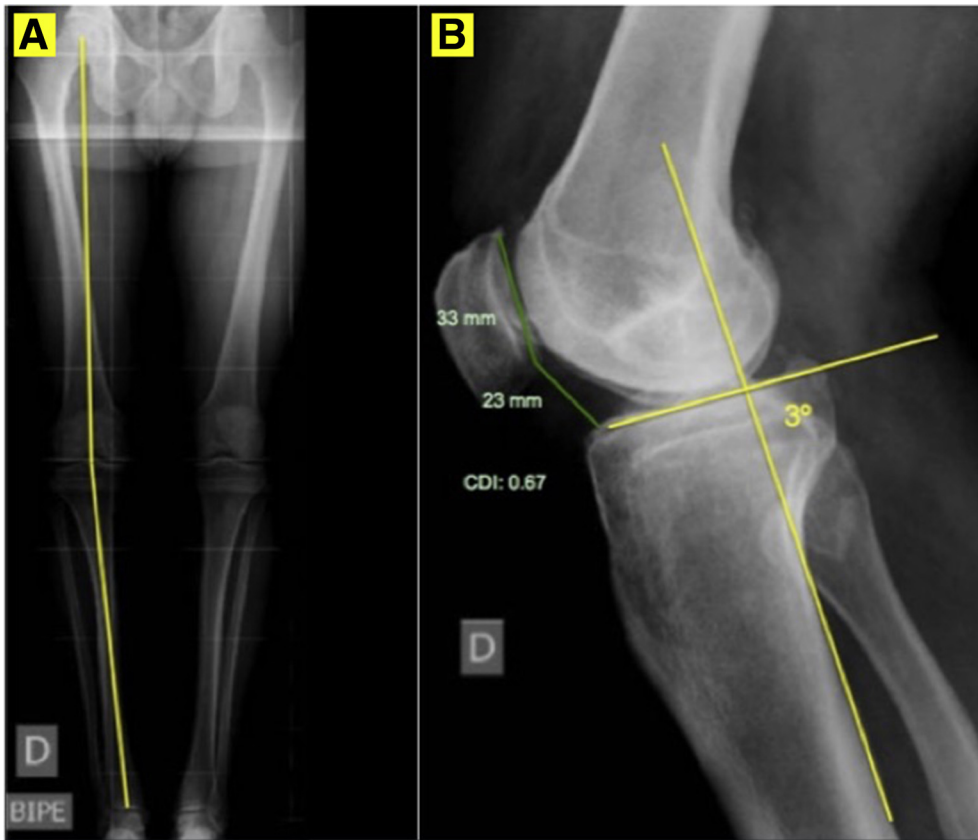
(A) Full-weight-bearing long-leg standing anteroposterior radiographs. (B) Measurement of the Caton-Deschamps index (CDI) and the posterior tibial slope (TS).
